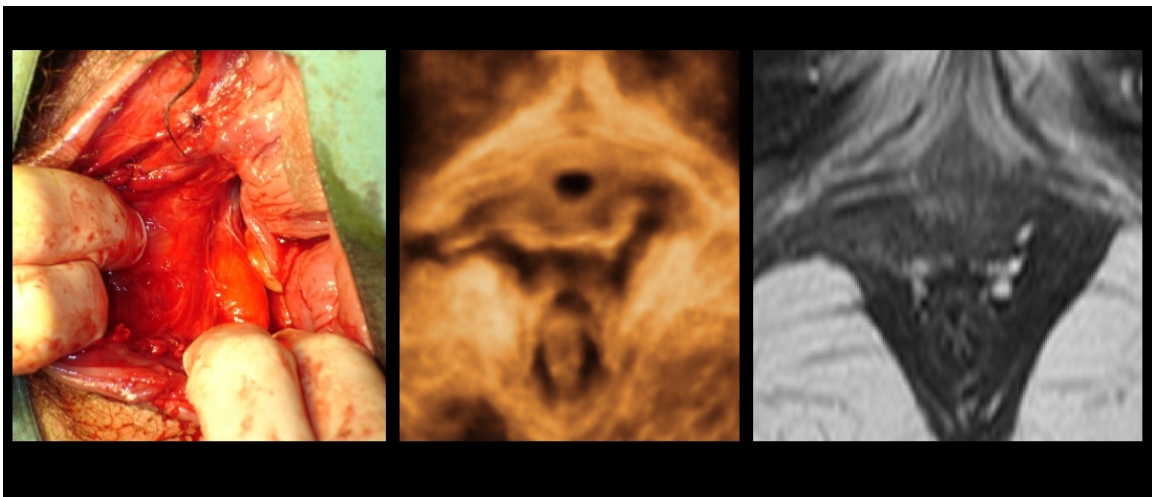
Major levator trauma as seen through a large vaginal tear after vaginal delivery (left), on ultrasound (middle) and on MRI (right) 3 months post-partum. Reproduced with permission from Dietz et al, ANZJOG 2007.
